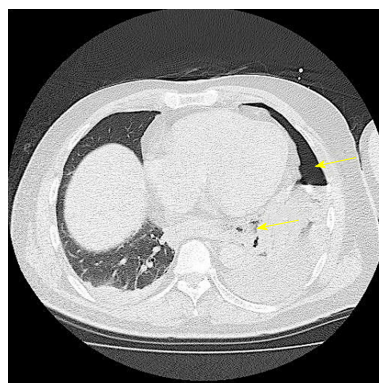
Chest computed tomography scan. Scan confirmed left pneumothorax (arrow) and mediastinal emphysema (arrow).
